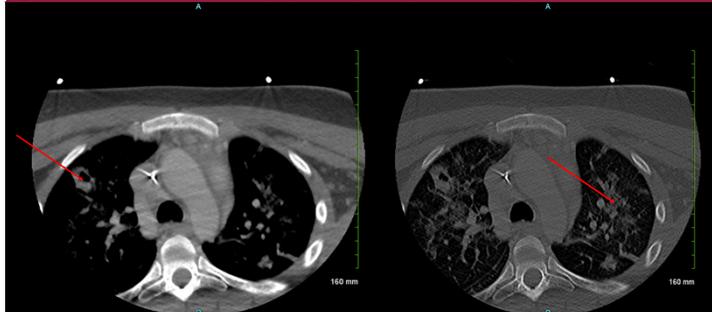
& 4 CT chest with contrast: multiple pulmonary cavitory and non-cavitory opacities
